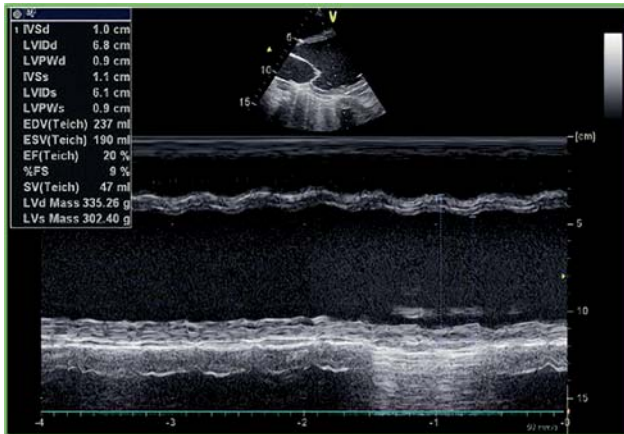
M-mode echocardiogram demonstrating left ventricular dysfunction.
